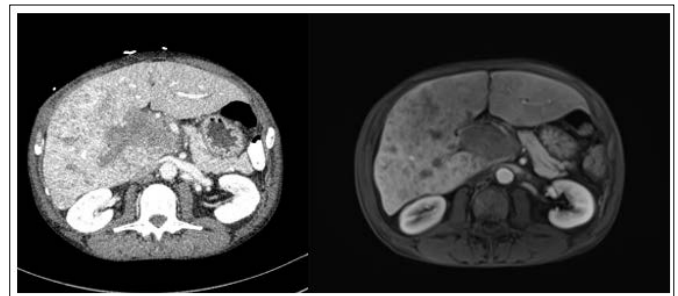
CT and MRI with Portal Venous Phase from the Same Patient Reveal an Expanded Portal Vein with Enhancing Intraluminal Material, Compatible with Tumor Thrombus
